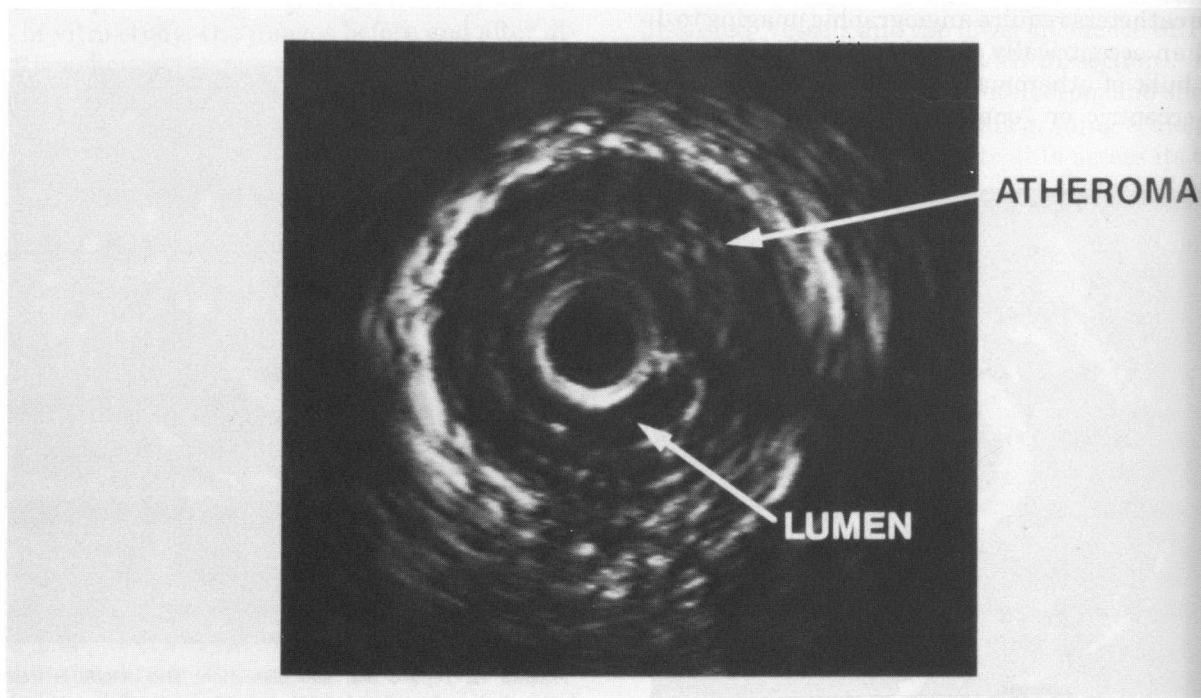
Type E1 morphology: A concentric atherosclerotic plaque with no evidence of dissection or plaque fracture by ultrasonic imaging. The mechanism of a successful angioplasty in these cases must be vessel stretching and perhaps a small degree of plaque compression. These lesions are at significant risk for vessel recoil and may have a higher restenosis rate. (Reprinted from ref. 22 with permission of the American Heart Association.)
